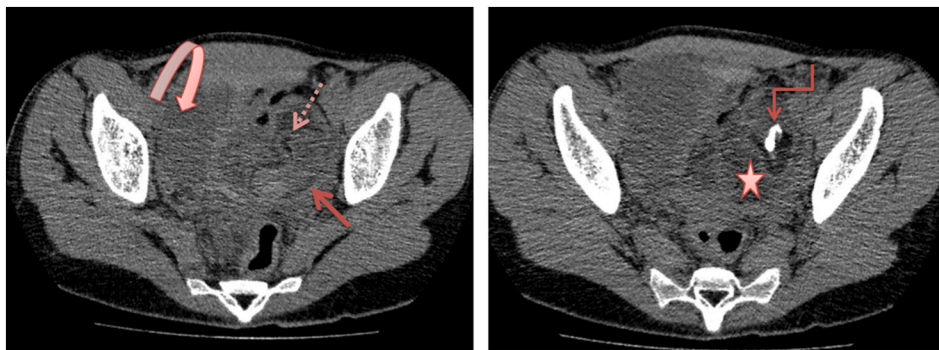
Axial CT: heterogeneous left ovarian mass (arrow) with fat (discontinued arrow), calcifications (angled arrow) associated to fat stranding (star). Note the cystic mass of the right ovary (curved arrows).
